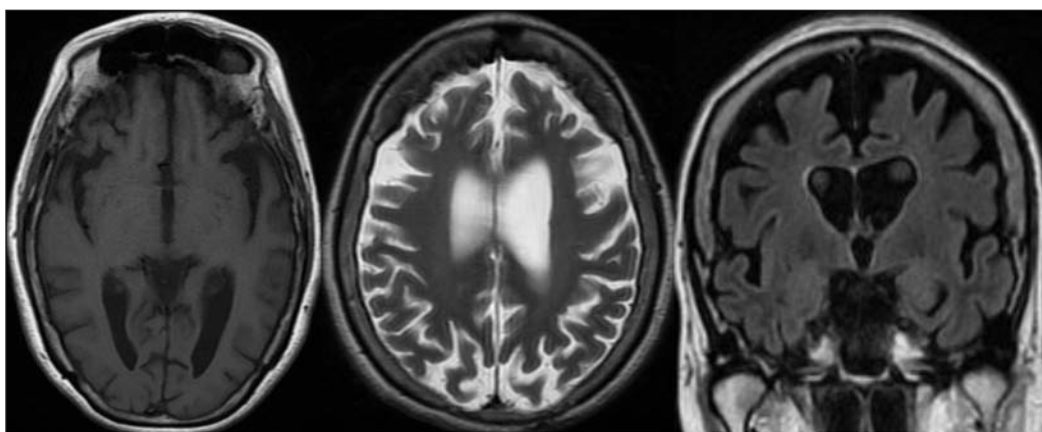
Axial T1, T2, and coronal FLAIR images of the patient's brain 18 months after the onset of symptoms.
